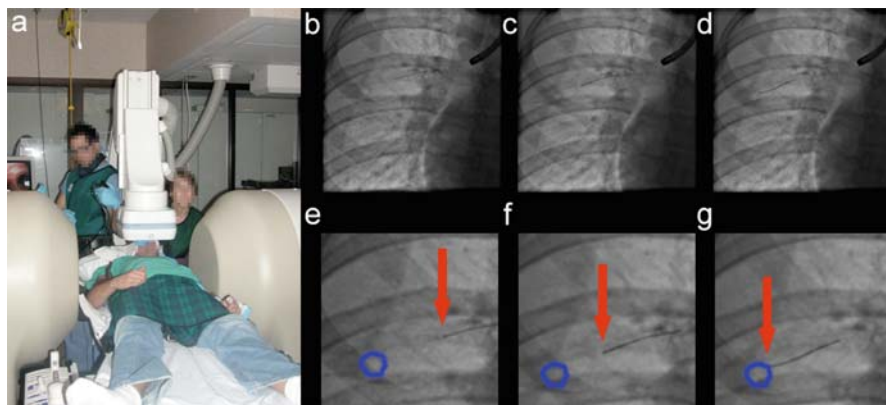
(a) Bronchoscopy procedure utilizing a Niobe Stereotaxis magnetic guidance system; (b–d) a series of chest X-rays depicting a ferromagnetic guide wire steered toward a peripheral nodule; (e–g) magnified series of X-rays shown in (b–d) with the guide wire tip indicated by a *arrow* and the boundary of the peripheral nodule circled
